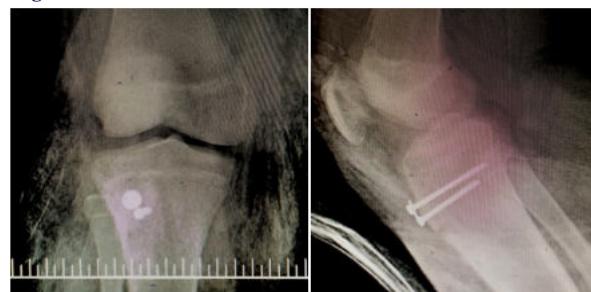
1st month follow up radiographs (under long leg cast).
